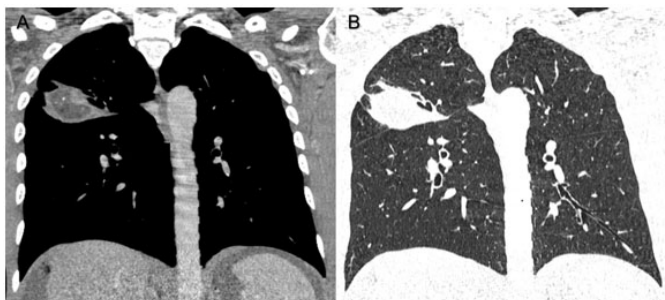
Enhanced CT thorax (coronal view) in (A) mediastinal and (B) lung window showing an irregular mass in the posterior segment of right upper lobe with central hypodense component and focal calcifications.
